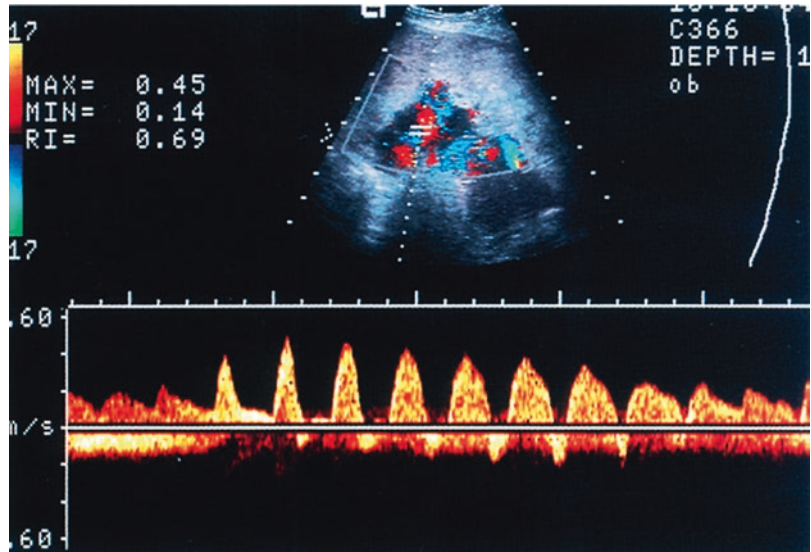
Doppler sonogram of the umbilical artery showing transient absence and reversal of end-diastolic velocity followed by prompt recovery of a discordant twin
